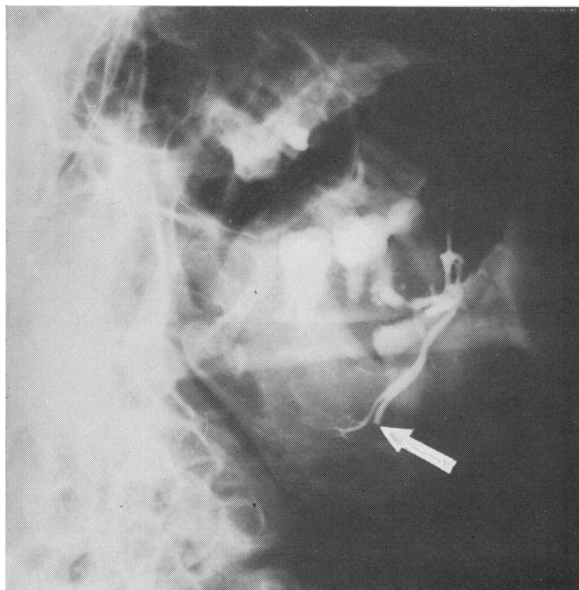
Sub-mandibular sialogram showing obstruction confined to secondary duct and due to a small calculus which did not show up on a plain X-ray.
